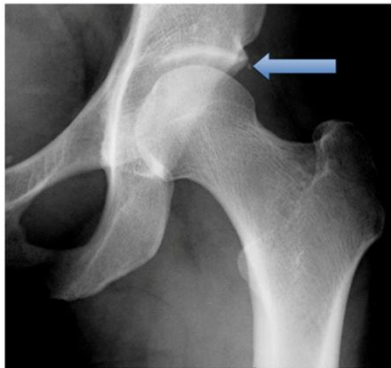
Pre-operative antero-posterior (AP) radiograph of the left hip in year old female patient shows a common location and appearance of AC (see arrow).
